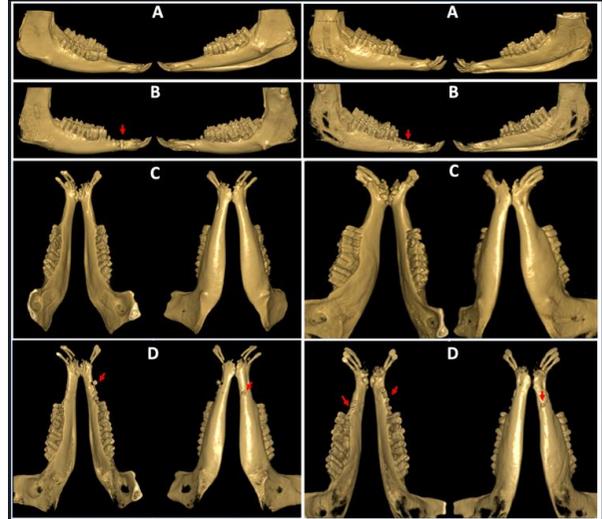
(A-D): Preop and postop 3D CBCT images. A: Preop right and left images. B: Postop right and left images. Placed implants and complications can be seen. C: Preop occlusal and inferior view. D: Postop occlusal and inferior view. Crestal bone defect and cortical bone perforation can be seen.
